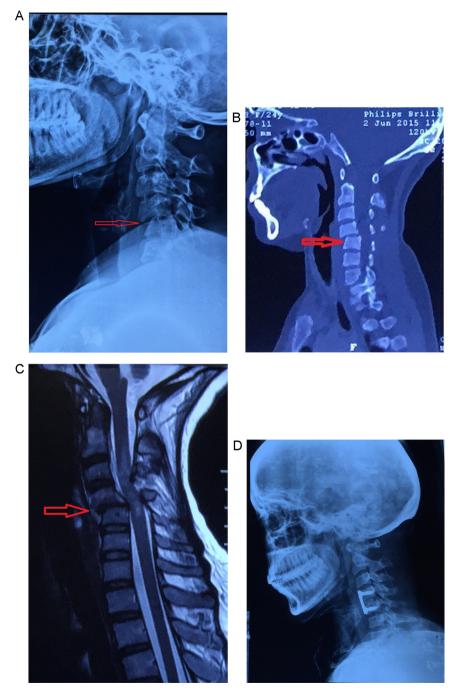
(A) Lateral view of cervical spine showing anterolisthesis of C4 vertebra over C5 with facet dislocation. (B) Sagittal section NCCT of cervical spine showing anterolisthesis of C4 vertebra over C5 vertebra without fracture of vertebral body. (C) T2 image MRI of cervical spine showing compression of spinal cord by extruded disc at C4–C5 level with myelopathic changes of spinal cord. (D) Post-operative lateral view of cervical spine showing cervical plate and screw with intervertebral tri-cortical iliac crest graft with good alignment and reduction.
